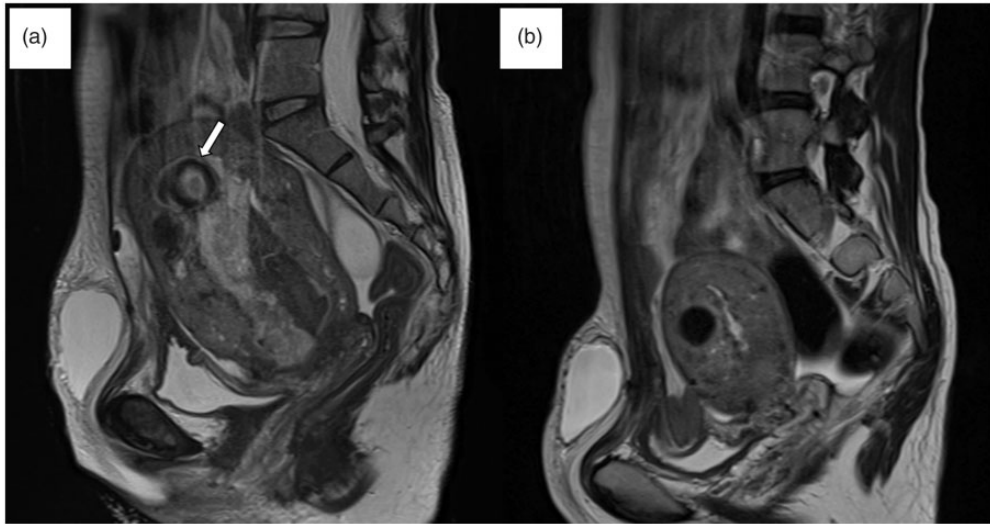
Magnetic resonance (MR) image of a uterine artery pseudoaneurysm (UAP). (a) MR image captured 2 days before UAP (arrow) rupture. (b) MR image captured 9 days after UAP rupture. No pseudoaneurysm is apparent. A uterine myoma is evident at the anterior wall of the uterus.
